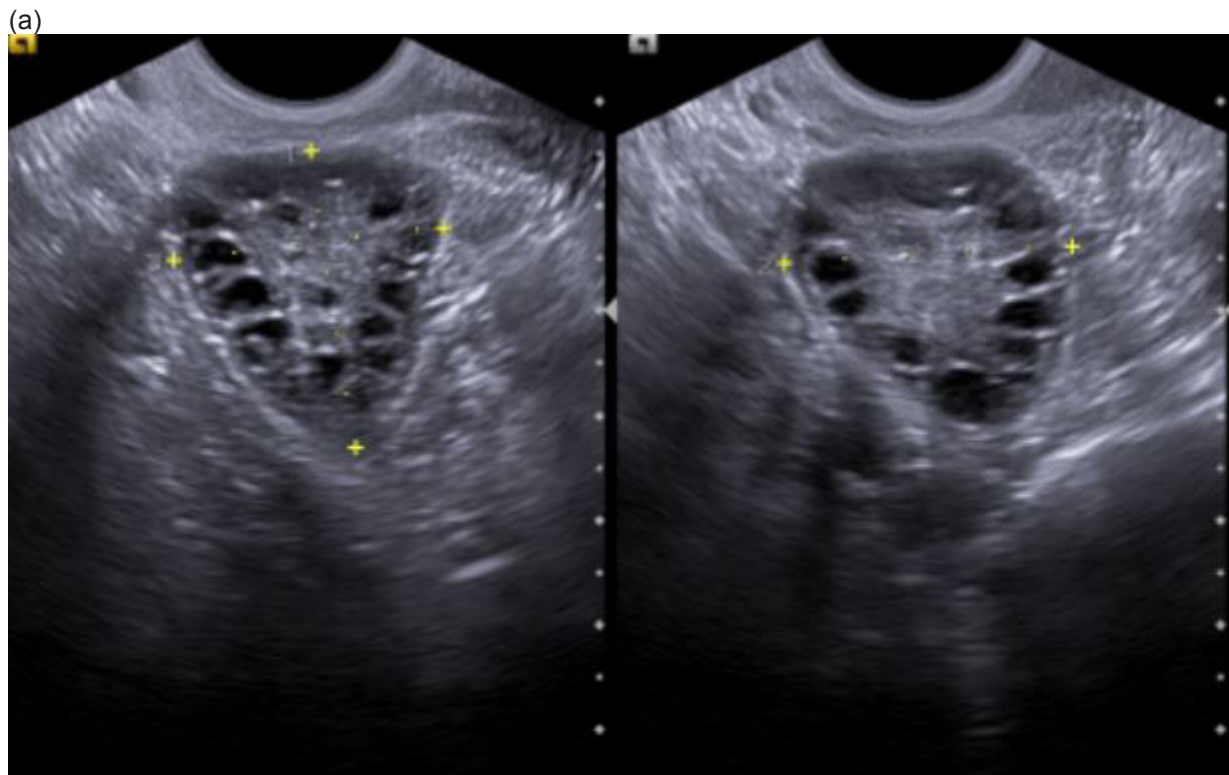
Ultrasound (a) and Doppler (b) of right ovary showing multiple peripheral small cysts with dense stroma.
